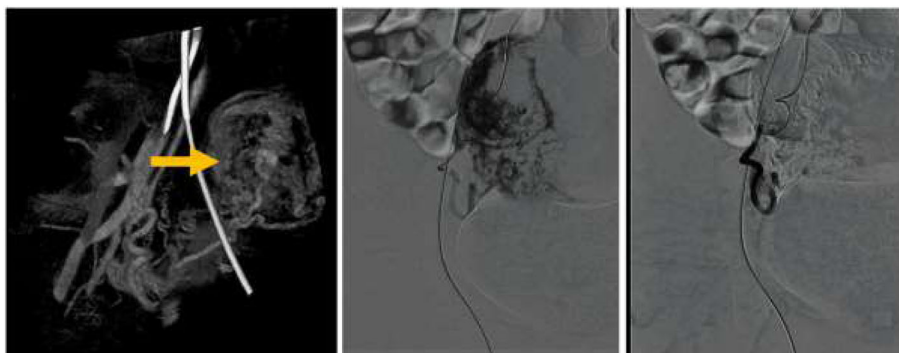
Case 2: Left: 3D CT angiography after contrast injection in the right iliac artery visualizing the right interstitial pregnancy (arrow). Middle: before embolization of the right uterine artery. Right: after embolization of the right uterine artery
